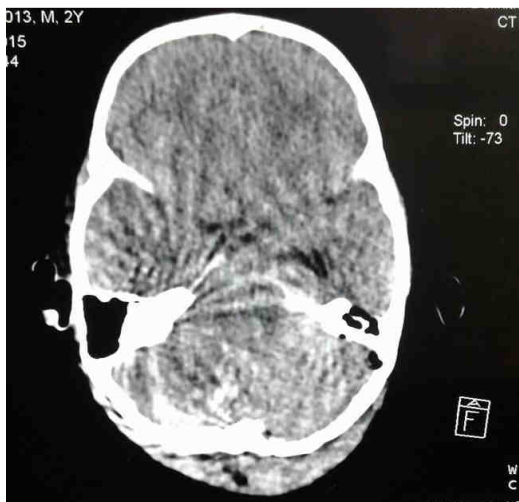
CT head showing cerebellar hematoma with SDH
